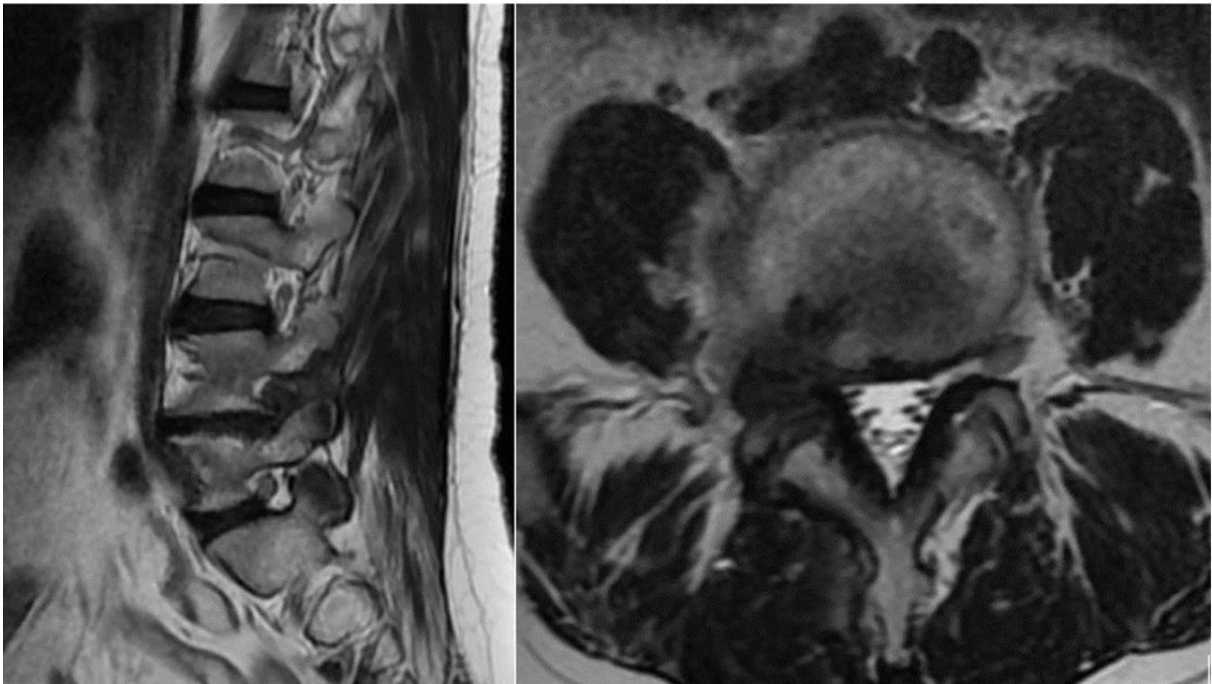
c.d. Lumbar magnetic resonance was performed because the patient had right radiculopathy 11 months after the surgery. Recurrent far lateral lumbar disc herniation was observed on magnetic resonance images
